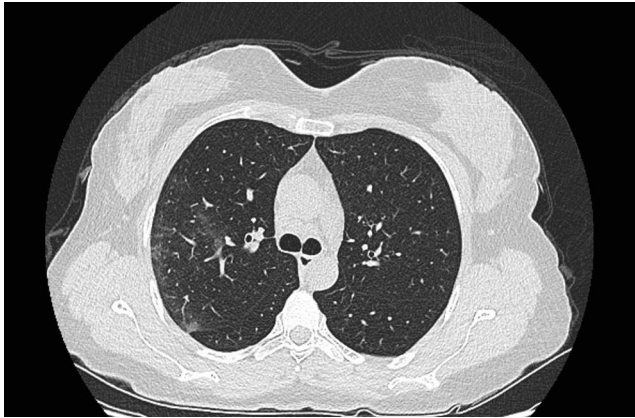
Transaxial chest HRCT scan showed bilateral and multifocal patchy ground-glass opacities (GGOs), (more in the right lung), predominantly located in the peripheral of the chest
